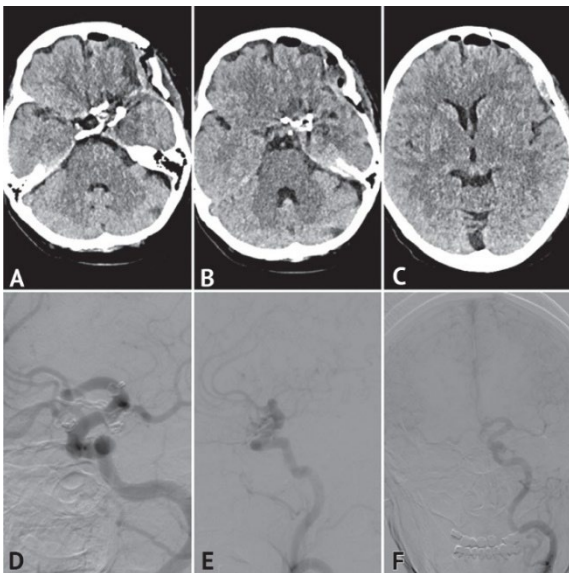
Postoperative computed tomographic (A–C) and angiographic control (D–F) of patient L. There are no signs of hemorrhage and foci of ischemia in the area of the operation according to computed tomography of the brain. According to cerebral angiography, the cavities of the aneurysms are not contrasted
